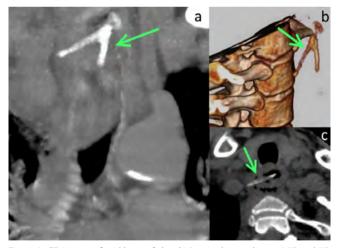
CT images of wishbone of the chicken in the esophagus. MIP and 3D images (a, b). Note that the chicken bone is extending outside the esophagus, representing esophageal rupture (c).
